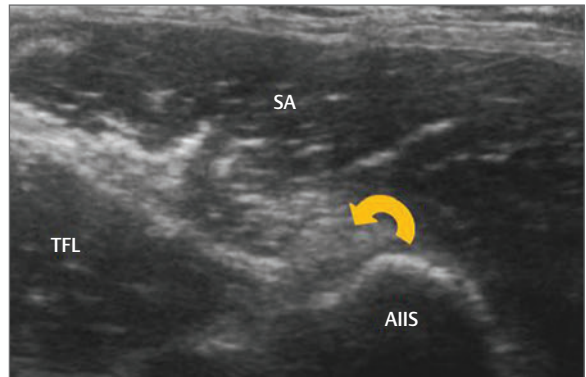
Ultrasound image of the anterior aspect of the hip and anterior inferior iliac spine (AIIS). The tendon of rectus femoris can be seen as echogenic foci anterior to the AIIS (curved yellow arrow). Laterally to the tendon and the AIIS, the muscle of tensor fasciae lata (TFL) can be seen. Sartorius (SA) can be seen overlaying the AIIS and rectus femoris tendon.
